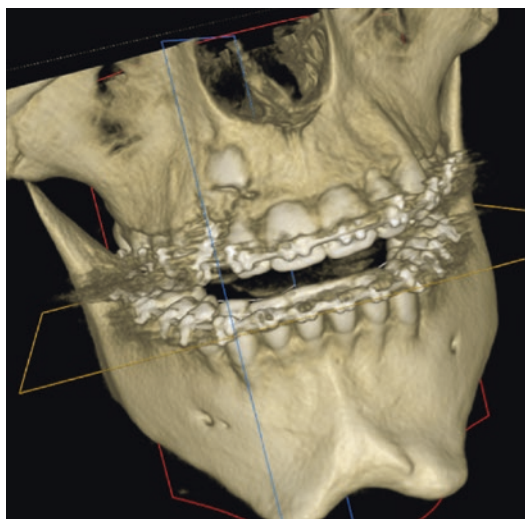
Cone beam CT. (Image courtesy of Dr. Robert Reti)
